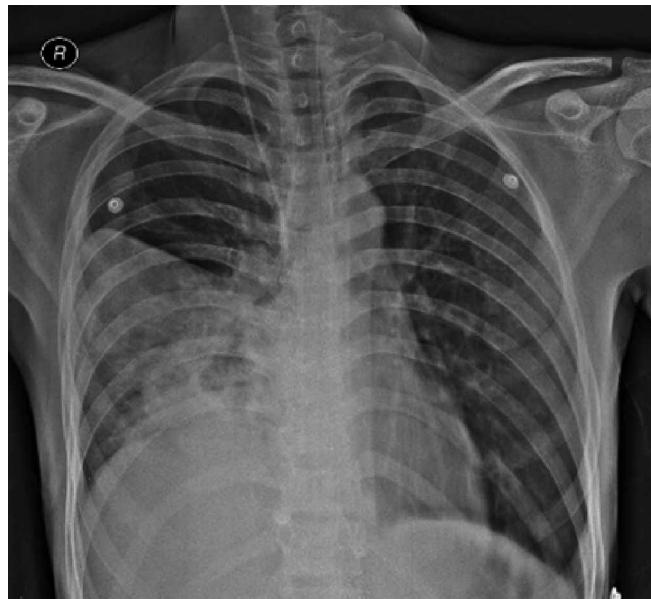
Chest radiograph at the time of admission.
